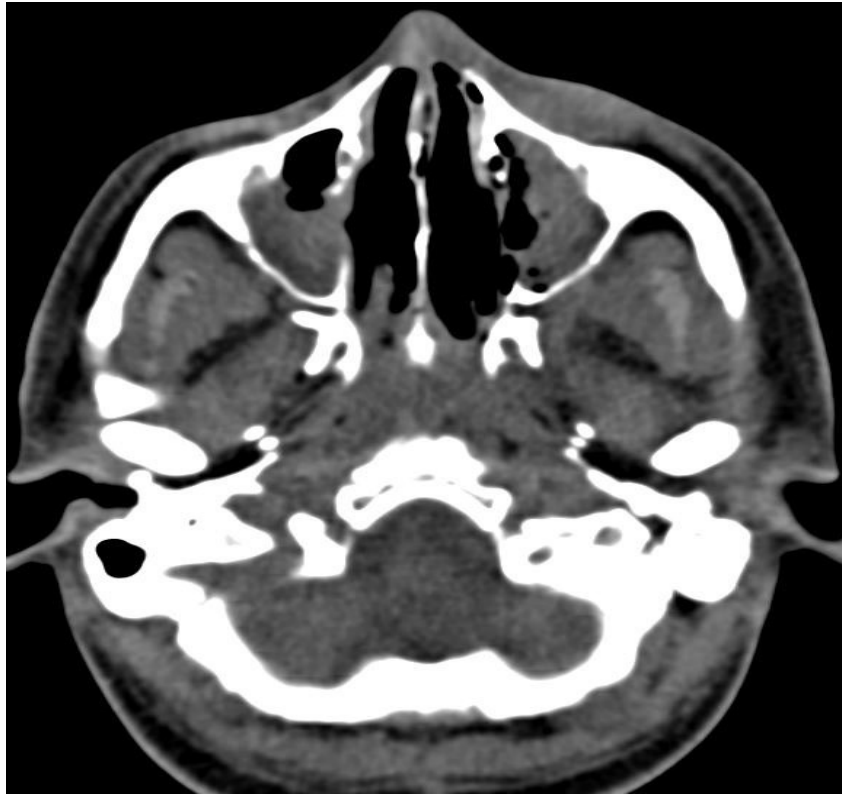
CT scan image shows Axial CT section bone window showing defect in the medial wall of left maxillary sinus and bilateral maxillary sinusitis
